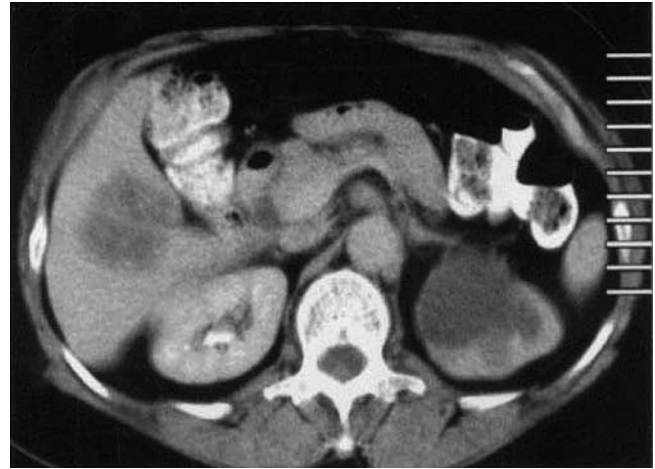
CT scan showing metastatic liver disease from recurrent rectal cancer.
